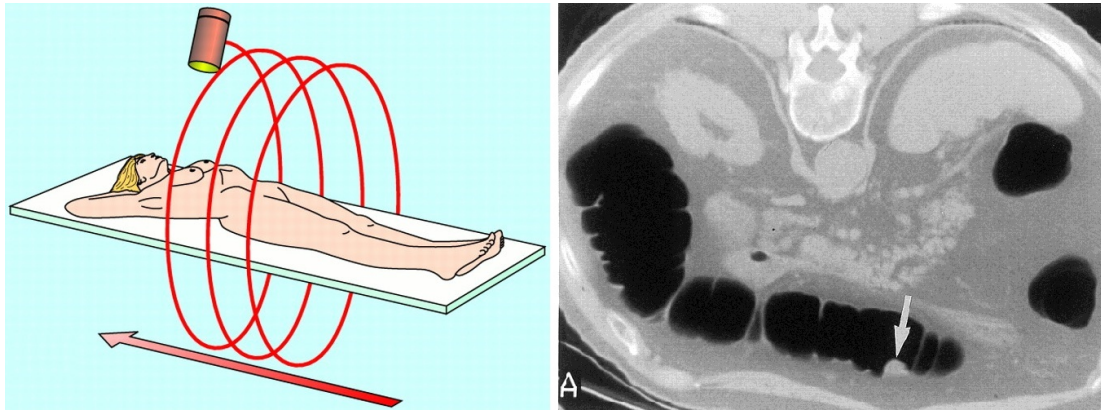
Spiral CT colonography of patient in supine position (left). The patient couch is moved while the x-ray tube rotates in the transaxial plane. A 10 mm polyp in the transverse colon (arrow) as visible in a CTC scan with the patient lying in prone position (right). The large intestine is inflated with air which enables a sharp contrast between the surrounding abdominal soft tissues and the colonic lumen. [Figures courtesy of Halligan and Fenlon (1999)]
